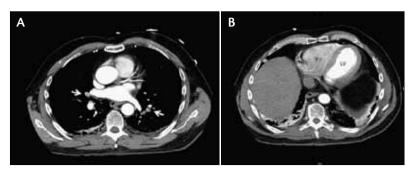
Bilateral PE predominantly affecting distal lobar vessels and segmental pulmonary arteries (A, arrows). The RV is in the upper limits of normal size, with no septal bowing (B). The LV is normal as confirmed on echocardiography. The blood pressure was normal. The BNP and troponin findings were negative, and the oxygen requirement was 4 L/min. The patient was successfully anticoagulated.
